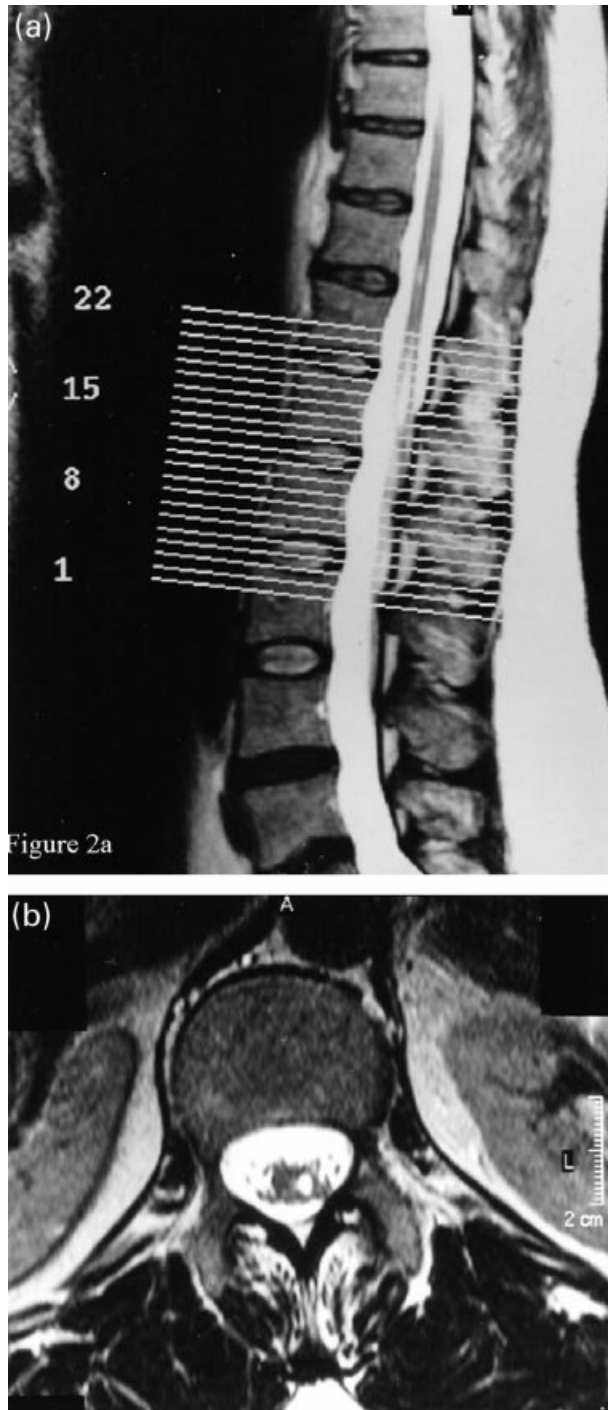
Magnetic resonance imaging scan using T2 weighting, in case 3. The end of the cord is less clear in this sagittal image (a), which appears to show several vacuoles, but the syrinx is clearly visible on the left side in (b), the axial view at cut 17 in (a).
